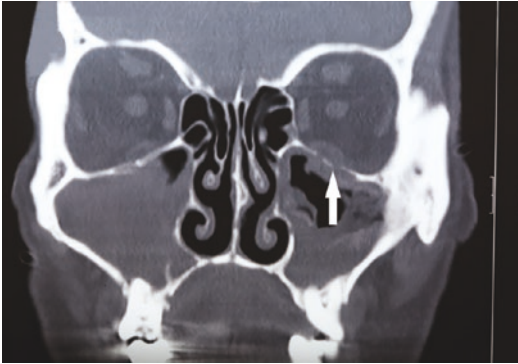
CT scan of a patient suffering from mucormycosis. The white arrow points to the erosion of the orbital floor by the fungus. Of note is the normal looking nasal cavity even though both maxillary sinuses are involved by mucor
